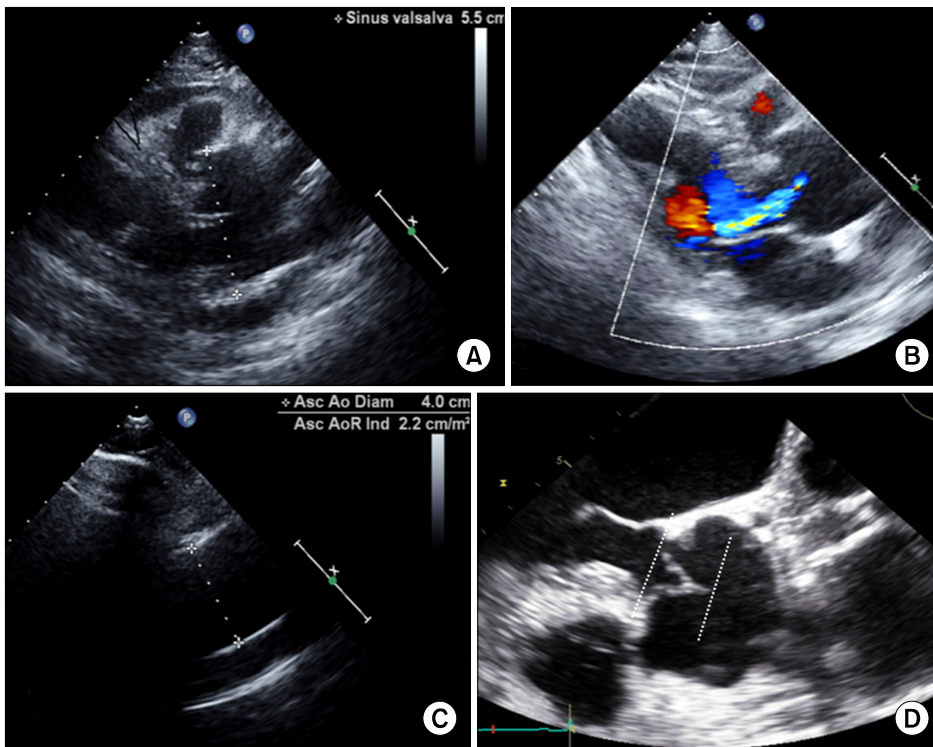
Preoperative echocardiography. (A) Transthoracic echocardiography shows an enlarged sinus of Valsalva (55 mm in diameter). (B) A parasternal long axis view shows moderate aortic regurgitation. (C) The maximal diameter of the ascending aortic tubular portion was 40 mm. (D) Transesophageal echocardiography shows cusp coaptation at a level close to the middle of the sinuses of Valsalva.
